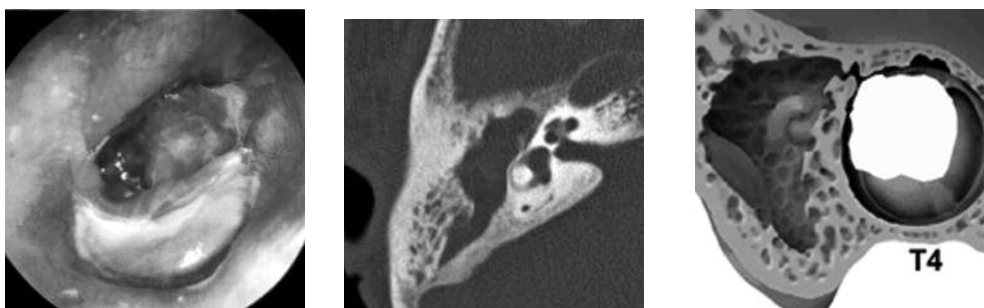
Otoloscopic and CT findings of case 3.
